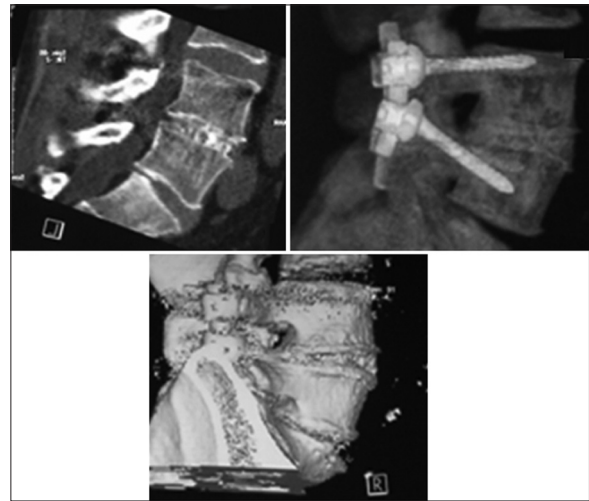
Follow-up CT images with 3-D reconstruction showing solid fusion (autologus bone graft)
